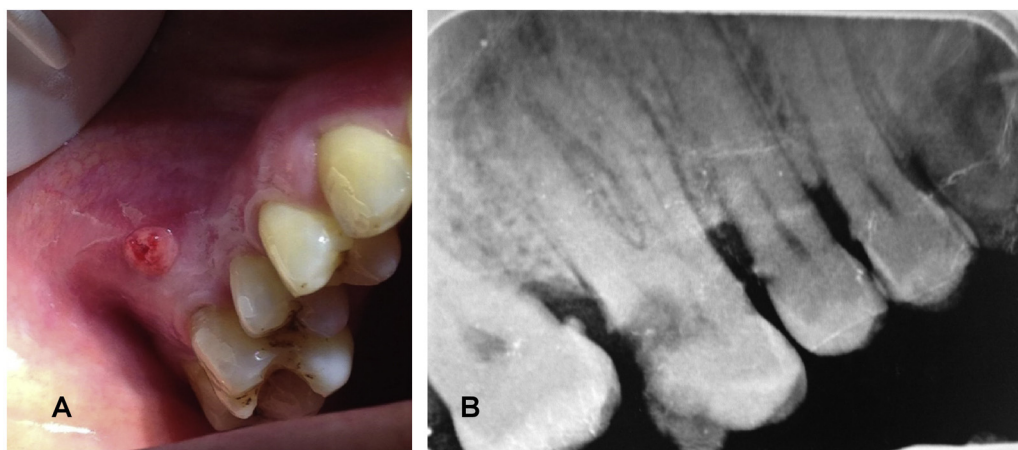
Clinical and radiographic views of oral acute infectious foci. A. Intraoral fistula of endodontic origin (necrosis of the first right molar). B. Intraoral radiograph showing a large decay affecting the dental pulp of this tooth and periapical radiolucency.
